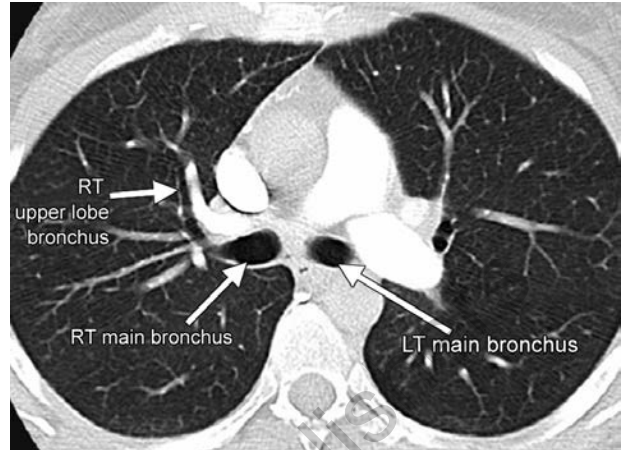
CT chest showing left and right main stem bronchi with the take off of the right upper lobe bronchus
